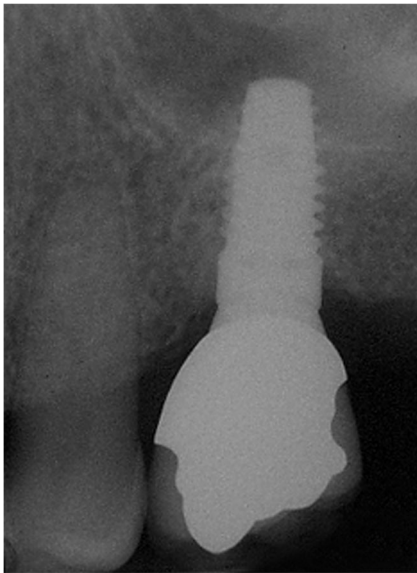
Radiograph taken after 3 years of function shows a low marginal bone loss as compared to prosthesis delivery stage
